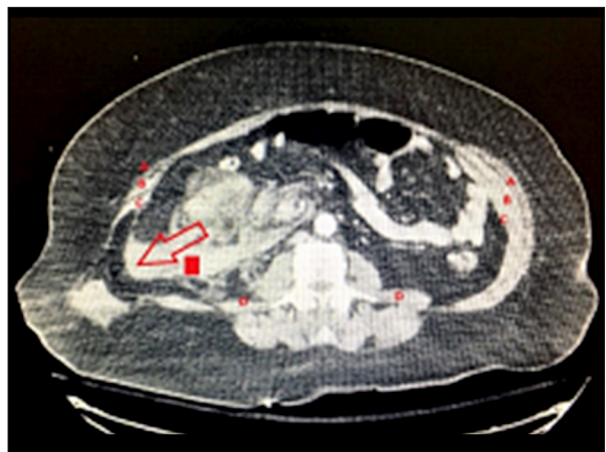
Axial CT image of the abdomen. This CT image depicts the right posterior traumatic abdominal–lumbar hernia defect with hemoperitoneum centered around the ascending colon (Arrow: right posterior traumatic abdominal–lumbar hernia defect. Square: hemoperitoneum. A: external oblique muscles. B: internal oblique muscles. C: transversus abdominis muscles. D: quadratus lumborum muscles).
